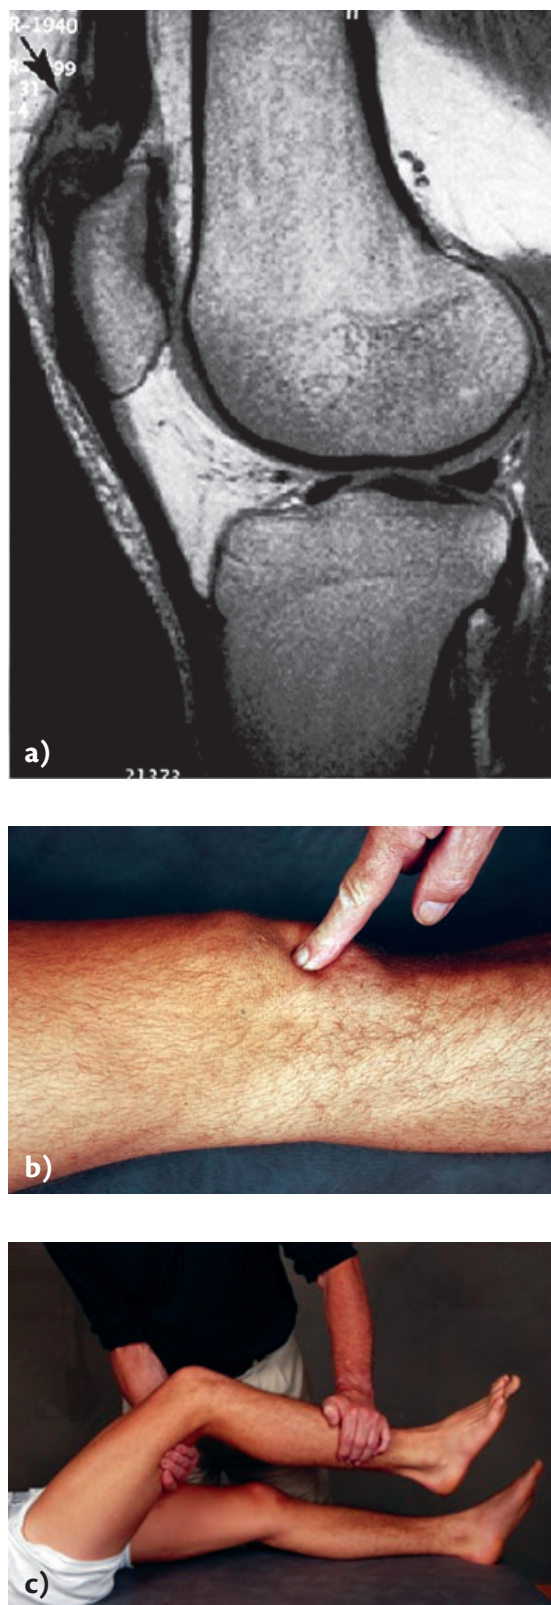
Examination of the knee joint. a) Magnetic resonance imaging of patella tendon. The arrow marks a partial rupture of the quadriceps tendon; b) the finger shows where the tenderness may be localized with an injured patella tendon; c) inability to actively extend the knee against resistance.
